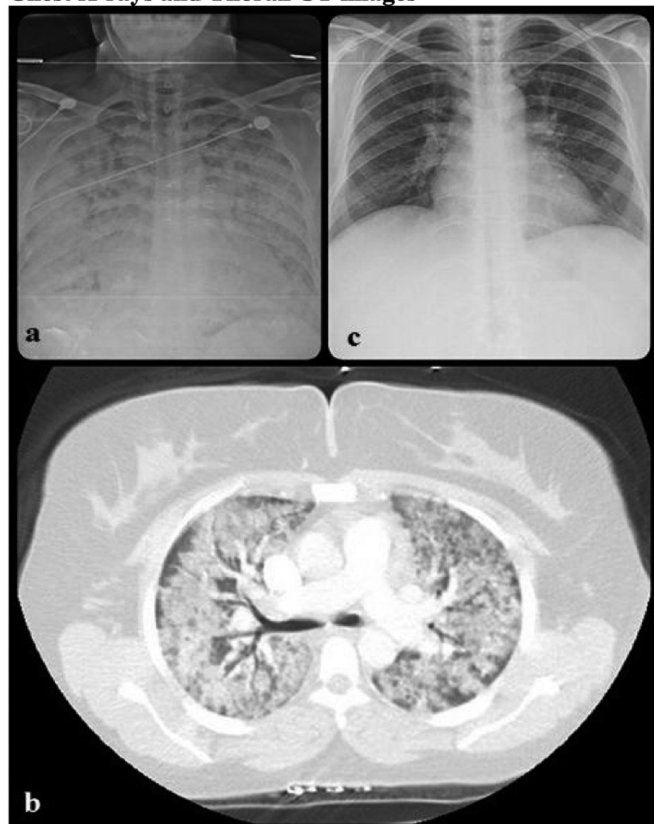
a. Bilateral pulmonary infiltrates in chest X-ray before treatment. b. Diffuse alveolar opacities, crazy paving pattern and areas of consolidation in thorax CT. c. Opacities completely resolved 2 weeks after the treatment.
